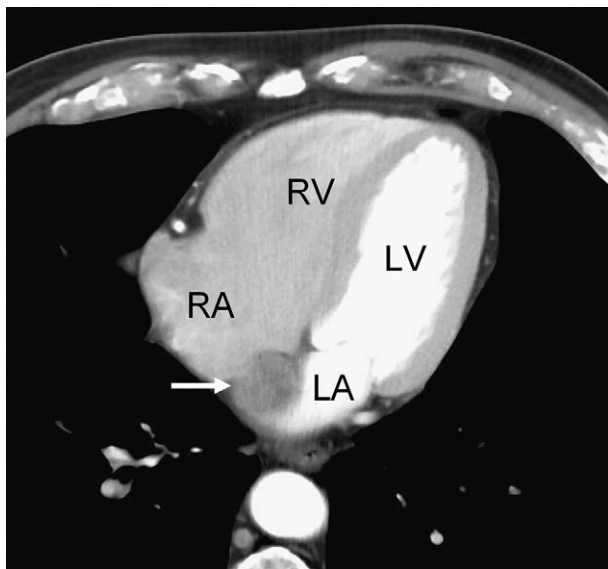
Follow-up, nongated CT of the chest with contrast, in the axial plane from a 75-year-old man with melanoma shows interval development of a heterogenous rounded mass located along the posterior region of the IAS most consistent with a metastatic lesion (*arrow*). RA, right atrium; RV, right ventricle; LA, left atrium; LV, left ventricle.
